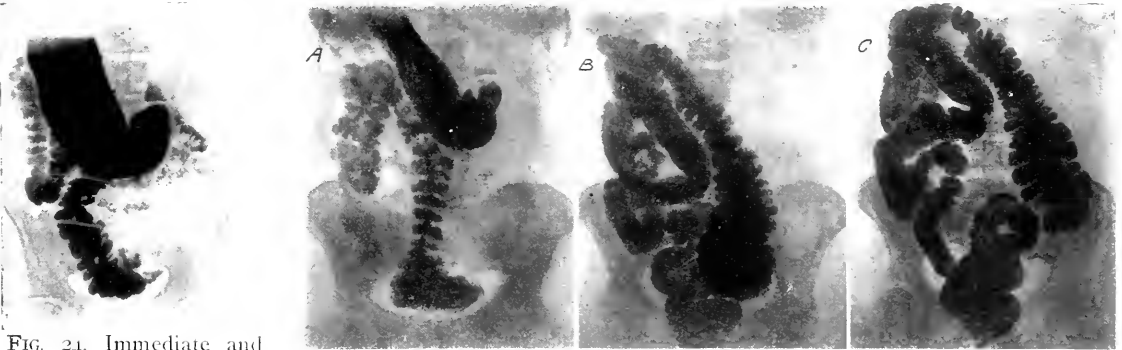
Immediate and twelve hour roentgenogram showing non-fused, non-rotated cecum with deficient migration.
